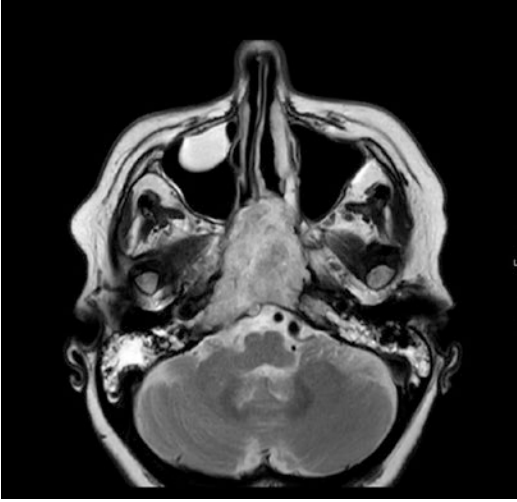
Pre-operative axial T2 MRI scan demonstrating significant expansile clival mass in keeping with chordoma
